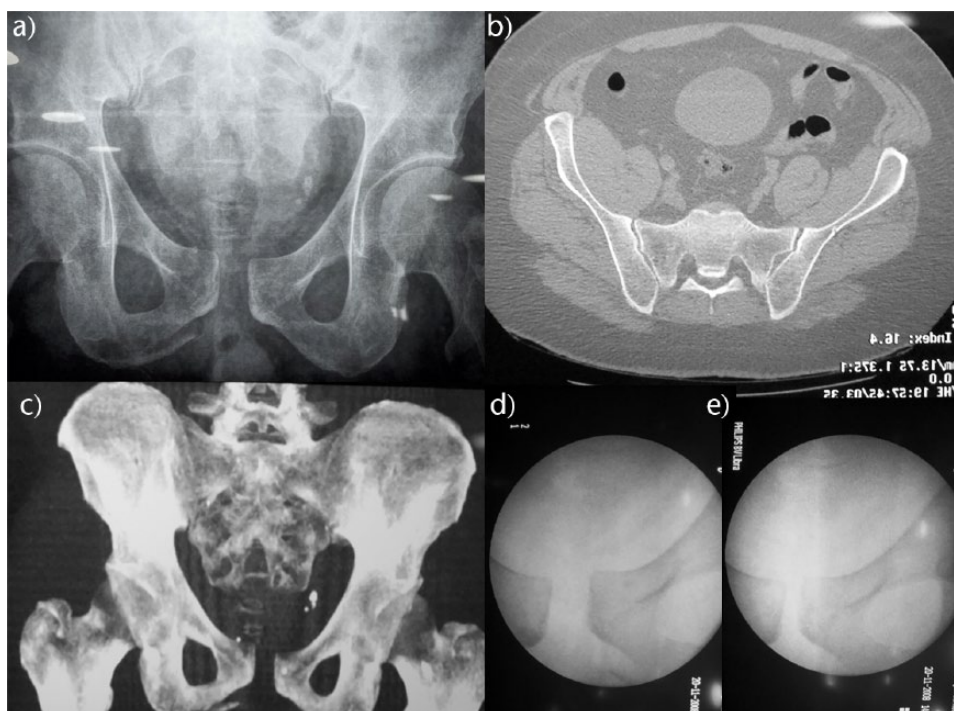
Type I residual instability of anterior rotational predominance: a) preoperative pelvic anteroposterior radiograph; b) axial CT scan; c) 3D reconstruction; d) and e) dynamic stability test under fluoroscopy showing pelvic instability.
